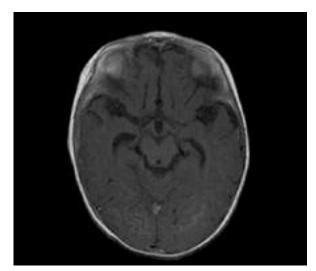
SE/T1 weighted MR images after enhancement – in the cortex of occipital lobes more visible hyperintensity of signal suggestive of cortex passive hyperaemia.
